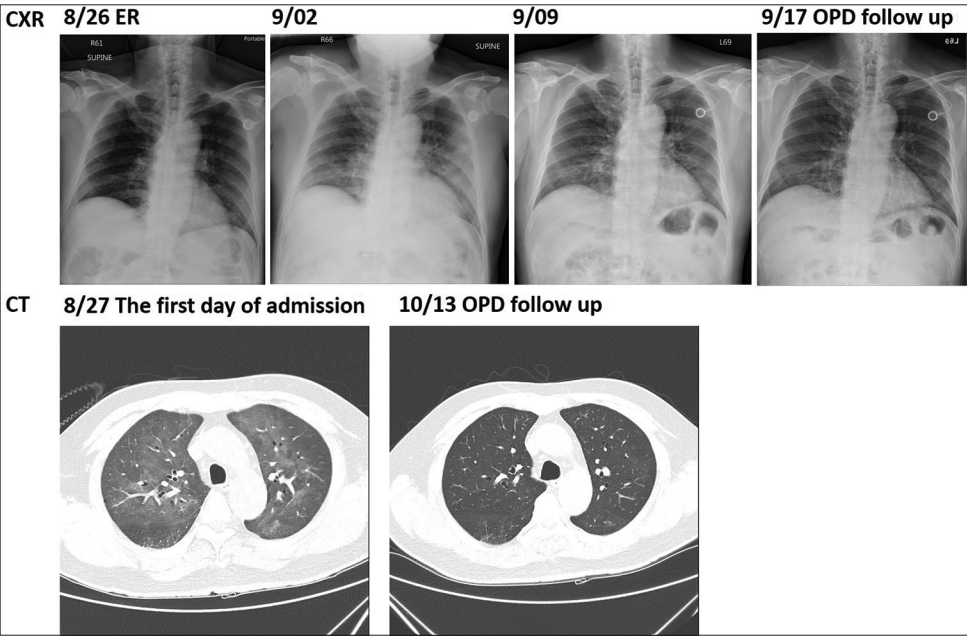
Images of chest X-ray (CXR) and Chest computed tomography (CT). CXR on 8/26 shows image finding out of proportion to clinical SYMPTOMS in the early disease course. CXR on 9/2 reveals bilateral ground-glass opacity (GGO) compared with the image on 8/26. CT scan upon admission show bilateral GGO, suggesting *Pneumocystis jiroveci* pneumonia or Cytomegalovirus infection. Another CT scan follow-up in the outpatient department show bilateral ground-glass opacity significant in regression. CXR: Chest x-ray, CT: computed tomography, OPD: Outpatient department
